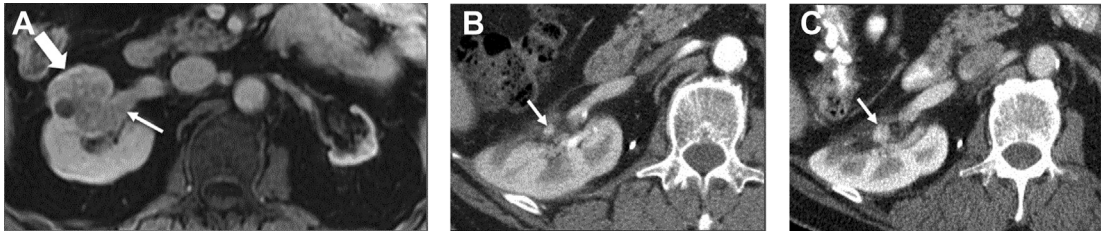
(A) Contrast-enhanced T1-weighted MR image from a 67-year-old man with atrophic left kidney and right renal tumor (*large arrow*) with renal vein invasion (*small arrow*) treated with preoperative pazopanib followed by partial nephrectomy. (B) One-year follow-up CT image shows a 5-mm enhancing nodule (*arrow*) at the resection site, not identified by the interpreting radiologist. (C) Two-year follow-up CT image shows increase in size of nodule (*arrow*) to 1.2 cm. The patient underwent cryoablation for recurrence. Recurrent disease most commonly demonstrates rounded, convex margins, may hyperenhance (in cases of ccRCC), and increases in size over time.
